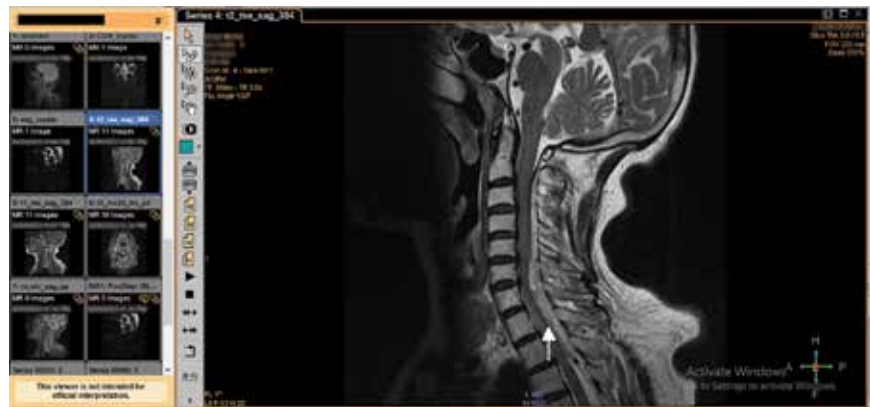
Sagittal view of the cervical spine MRI. (Hematoma is pointed by arrow).
